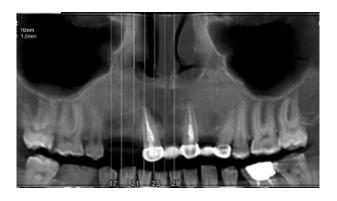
CBCT radiograph demonstrates the success of bone regeneration.
